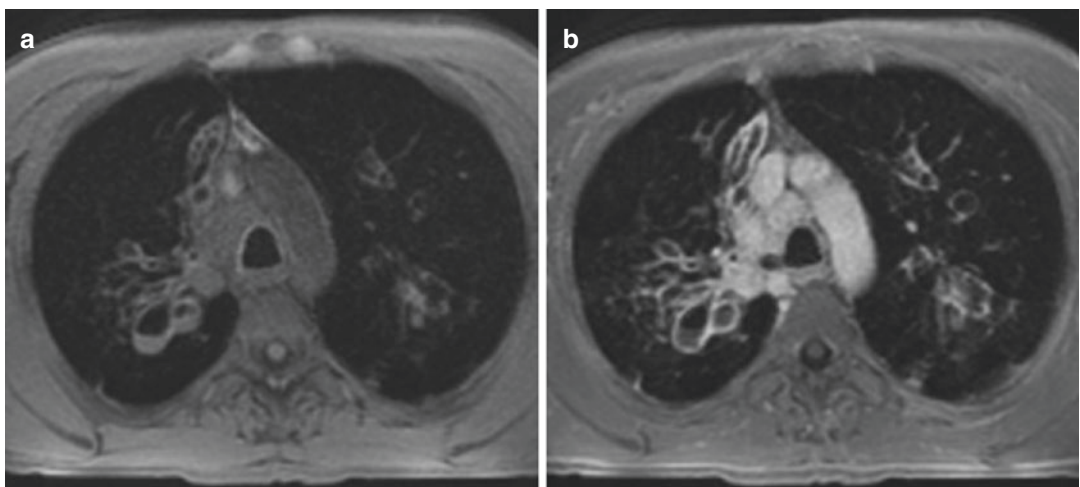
T1 weighted MR images of a 43-year-old CF patient (a) pre- and (b) post-contrast media: contrast enhancement. The post-contrast images demonstrate extensive bronchial wall enhancement and permit differentiation of a thickened wall from intrabronchial secretions, with intrabronchial
